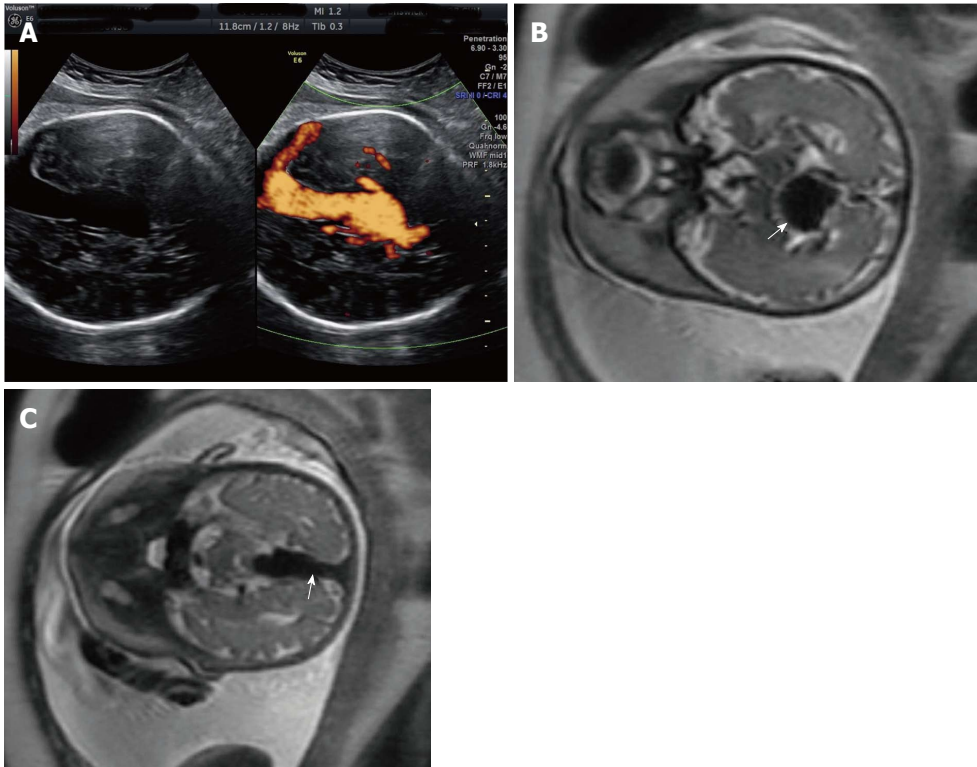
A 42-year-old G2P1001 presented for a routine growth ultrasound at 36 wk 5 d. A: Prenatal ultrasonography shows vein of Galen aneurysm and color flow examination reveals a turbulence flow in the lesion and in the connected strait sinus; B: Prenatal T1-weighted magnetic resonance images show the markedly enlarged median procerebral vein of Markowski, characteristic of vein of Galen aneurysmal malformation (arrow); C: Persistence of the falcine draining sinus (arrow).
